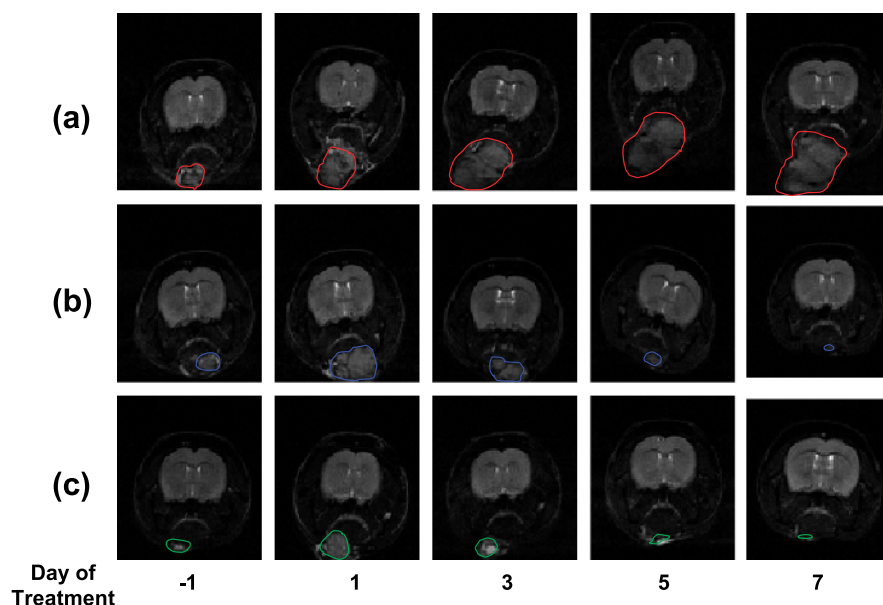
Submental tumor growth. Sequential T2-weighted MRI images of a slice through a control (A), a 5FC-treated (B), and a 5FC and radiation-treated (C) γCD -expressing SCCVII tumor. Images were acquired 1 day before therapy and 1, 3, 5, and 7 days after therapy. The submental tumors are indicated by the red, blue, and green regions of interest, respectively.
